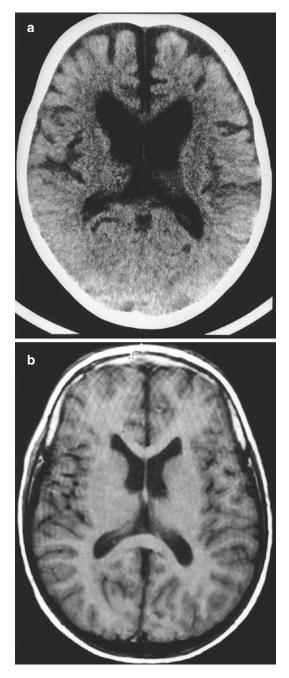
This CT scan presents reversible "pseudoatrophy" in a patient on dialysis. (a) shows the presence of larger and misshapen lateral ventricles as well as widening of the subarachnoid spaces in frontal brain regions during dialysis. (b) shows an apparent resolution of these abnormalities in the same patient several years posttransplant. (Reprinted with permission from Wiley & Sons)
